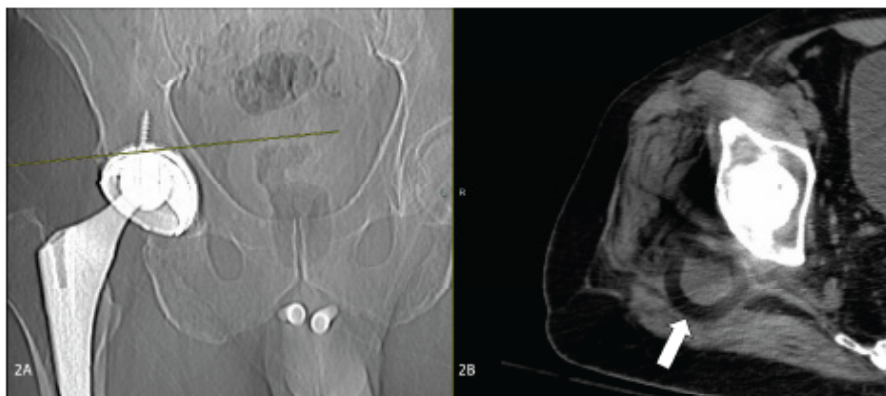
Images demonstrate the subtle ‘bubble’ sign on X-ray and CT confirmation of liner dislodgement, helping emergency physicians recognize this complication.*
